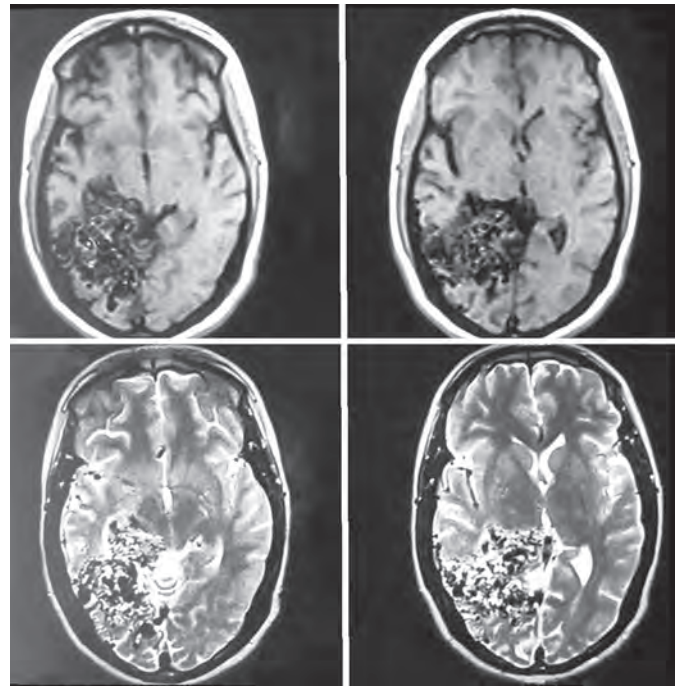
Magnetic resonance imaging will show areas of serpiginous flow void on T1-weighted and T2-weighted images
